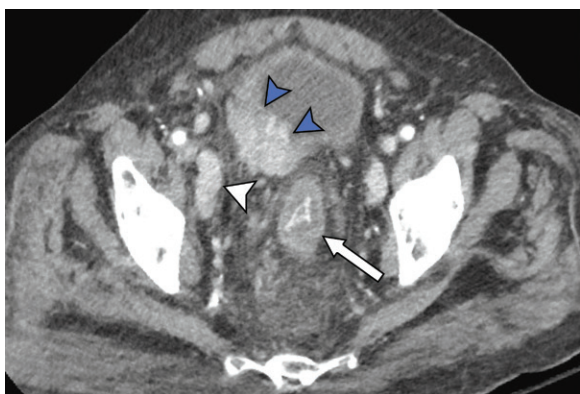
Radiation proctitis in a 67-year-old man with bladder and prostate carcinoma who was recently treated with radiation therapy and presented with lower abdominal pain and hematochezia. Axial portal venous phase CT image shows circumferential rectal wall thickening and edema (arrow), with perirectal edema that is consistent with the patient's history of radiation proctitis. Also noted is a mass representing bladder carcinoma in the right posterior bladder wall (blue arrowheads) and right external iliac lymphadenopathy (white arrowhead).
